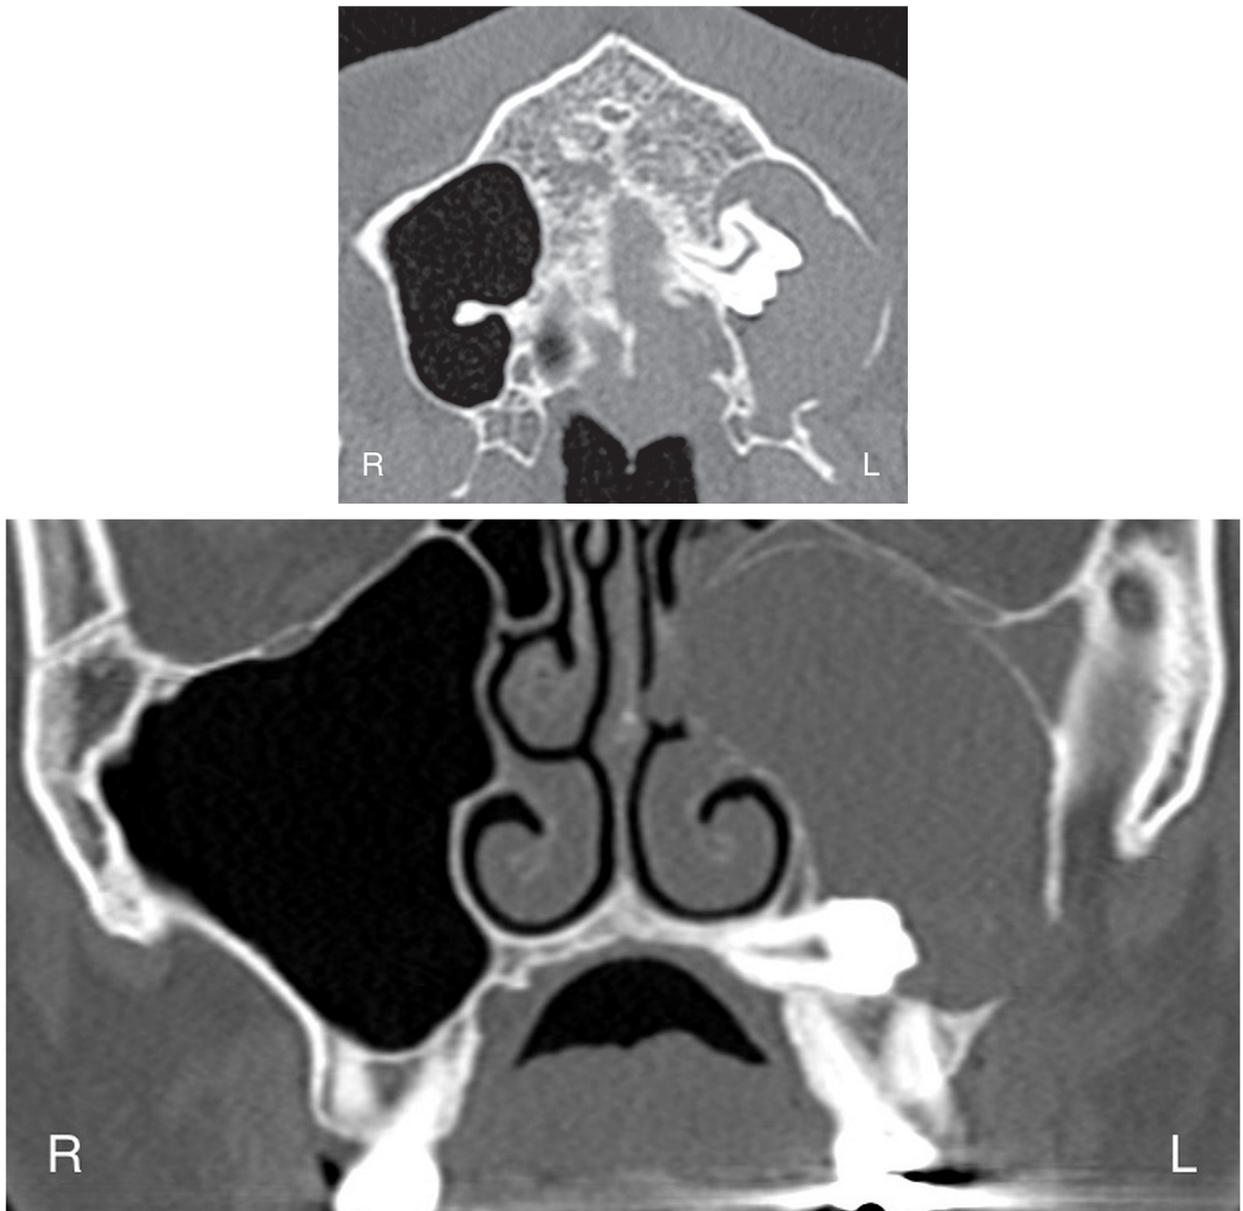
Preoperative CT scan. One of the roots of the third molar is inserted in the palatal bone, and the crown is in the sinus cavity, surrounded by a radiopaque neof ormation, which seems to entirely fill the antrum. On the most cranial area of the sinus, a separate bony wall is visible in the coronal view. 2.a Axial view. 2.b Coronal view.
